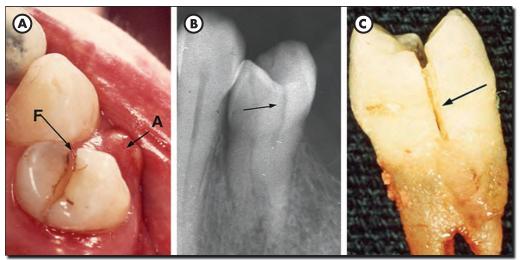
A split tooth where the mesio-distal fracture has resulted in separation of the segments. B. A radiograph of the tooth in Fig. 4A where the fracture is clearly seen. C. Separation of the fragments resulting in the split tooth is shown (arrow).
